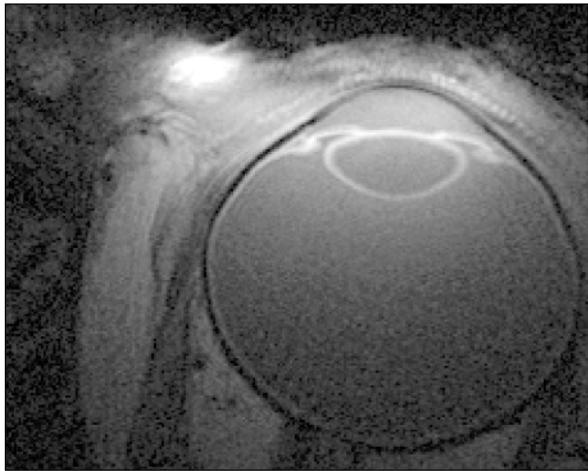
High resolution MR image; note reproduction results in some loss of image quality.
